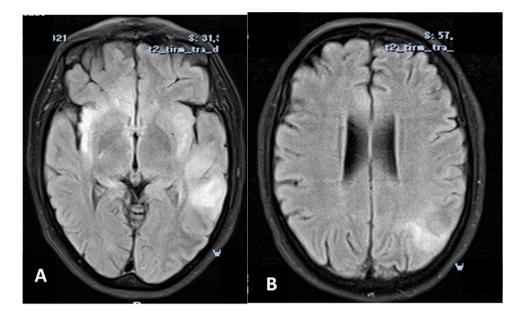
MRI axial FLAIR sequences revealed extended hyperintensities to occipital (A) and frontal lobes (B) in case no. 1, 28 days after COVID-19 vaccination
